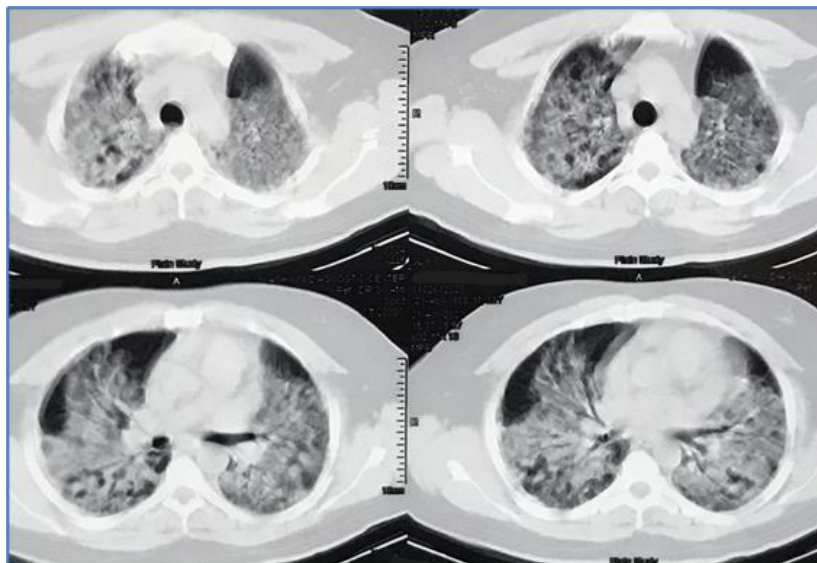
HRCT thorax showing bilateral GGOs and consolidations in upper and middle lobes
